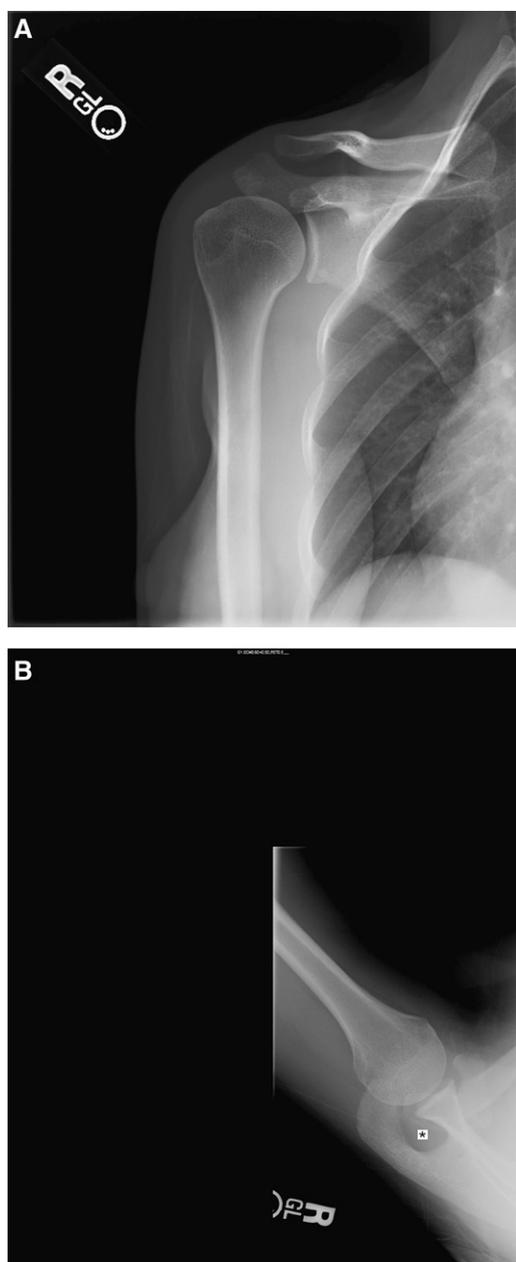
(A) AP and (B) axillary lateral radiographs of a normal shoulder representing standard radiographic technique. The *asterisk* marks the “eye” of the spinoglenoid notch.
